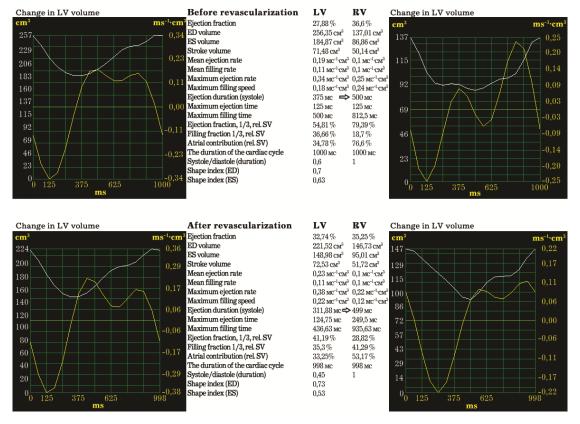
Hemodynamic curves of the left and right ventricles as per perfusion single photon emission computed tomography in patient
